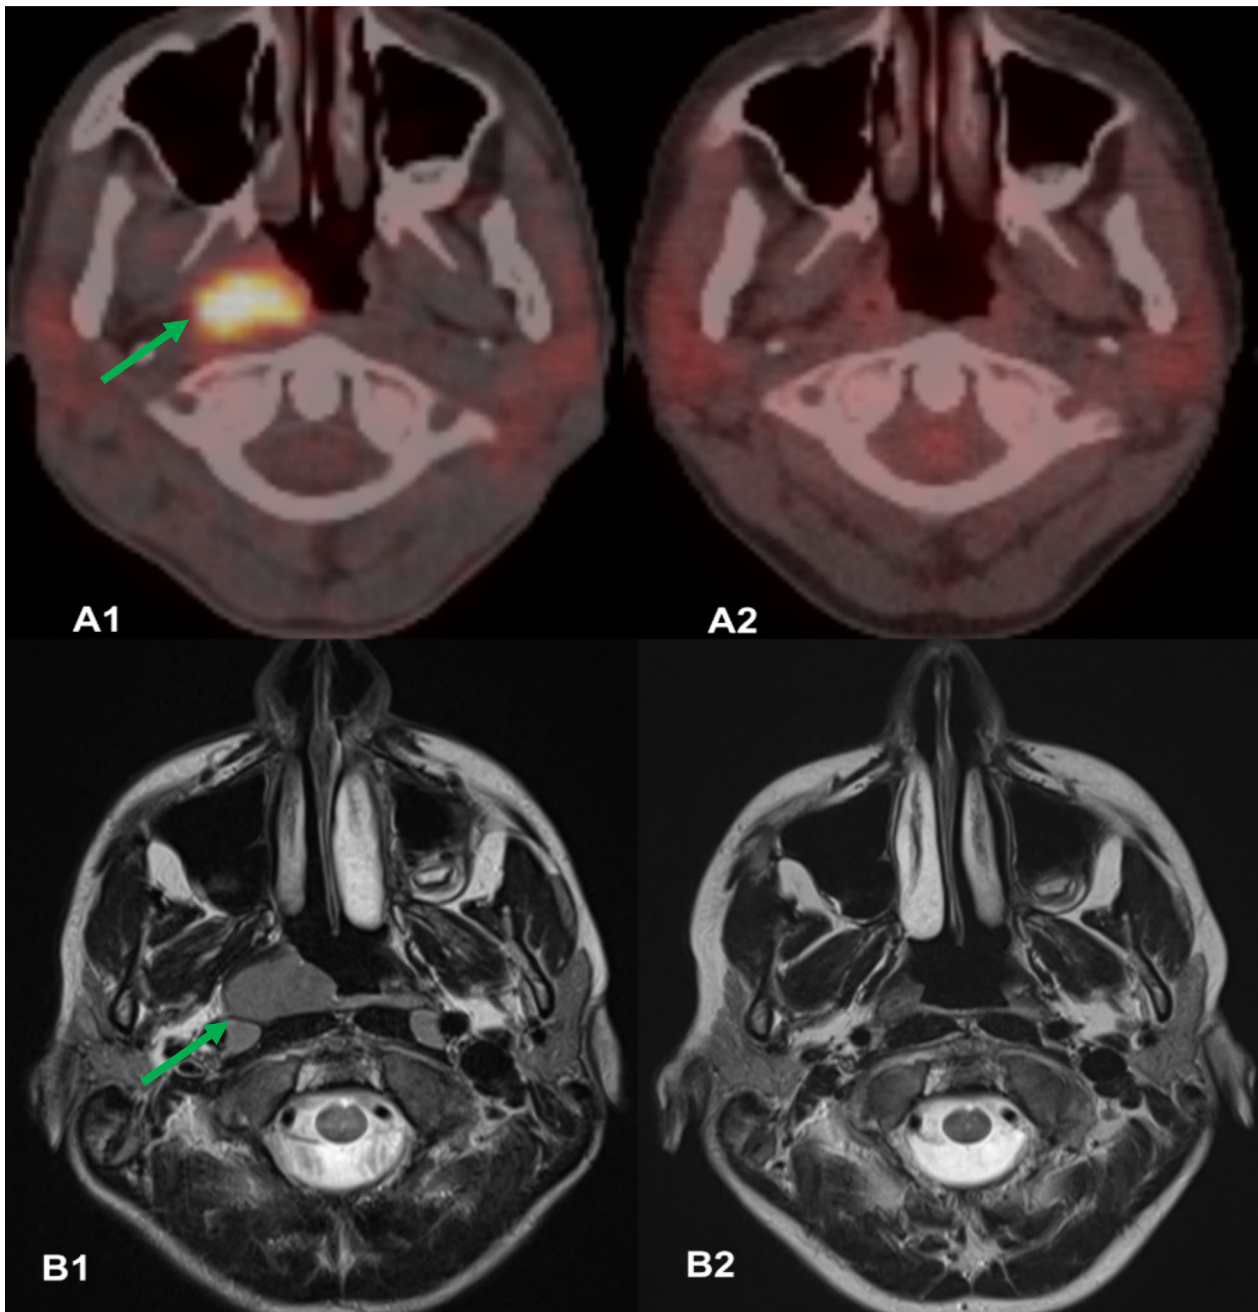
Combined low-dose ^{18}F -FDG-PET/CT images (A1, A2) and MR images (B1, B2) show Waldeyer's ring involvement at initial staging (A1, B1) and normalization following two courses of OEPA chemotherapy (A2, B2)
